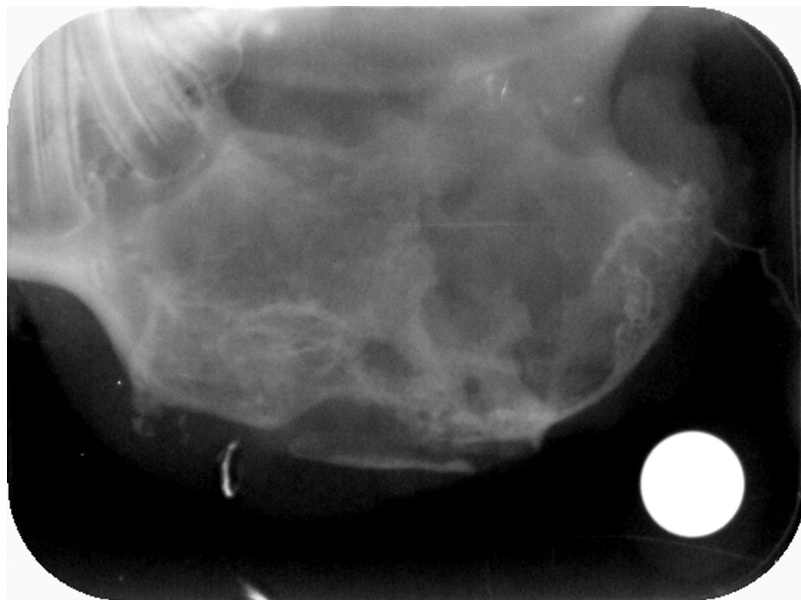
Digital radiograph from the left side (membrane only) at 24 weeks. The defect is almost completely ossified and it seems as if bone is growing along the membrane.
